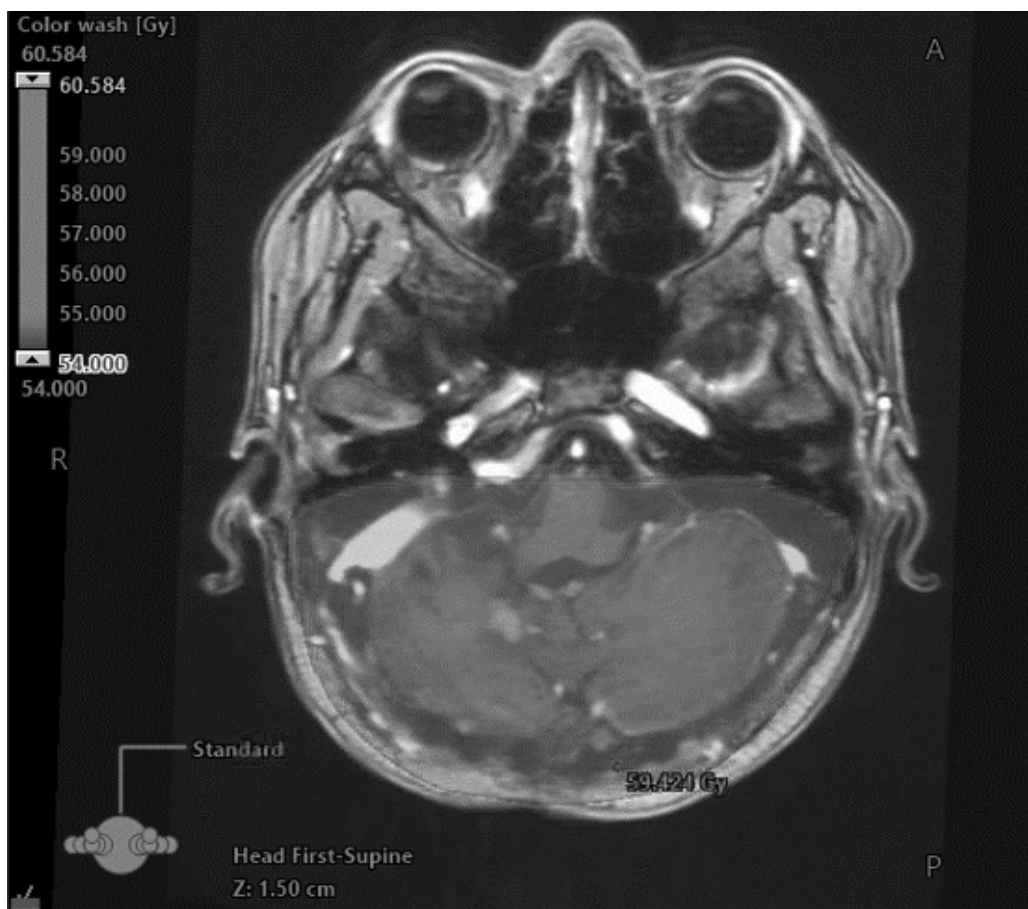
Fused follow-up MRI with planning CT shows local recurrence (arrow) within posterior fossa boost volume. Patient No. 6 underwent subtotal resection followed by radiation therapy alone. The local recurrence was detected 4.3 years after completion of radiation therapy.
